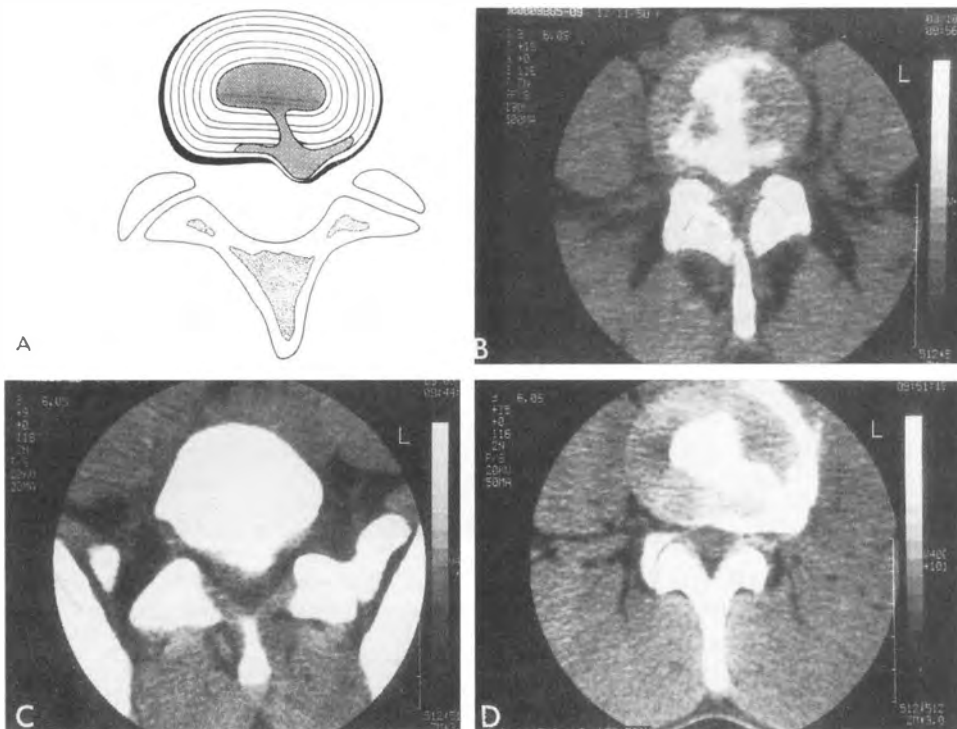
A and B. Pain may be the only abnormal finding in type II degenerated disc because insufficient anular tears exist for a radial fissure to be seen. (Reprinted with permission from Bernard T. Lumbar discography followed by computed tomography: refining the diagnosis of low back pain. *Spine* 1990; 15(7):690–707.)
